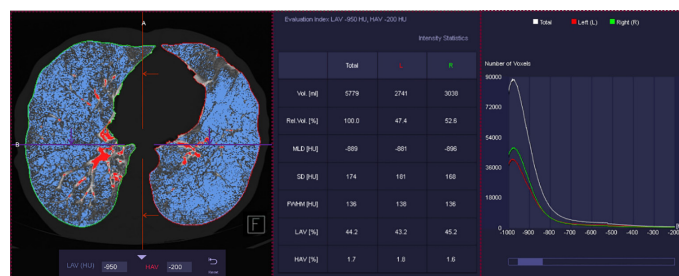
Measuring the Quantity of Emphysema (LAV%) and Lung volumes. Each result of the reconstruction was processed by using 3D Pulmo software in SYNGO.VIA Siemens workstation to measure the quantity of emphysema by displaying the Low Attenuation Volume (LAV) with HU values of -950 in percentage (%) and lung volumes by showing the symbol of vol in milliliter (ml). The software allows masking the area with certain HU and calculating automatically from Dicom formatted images of HRCT Chest. The area with <-950HU which is detected as emphysema is shown in blue while the airway showed in red.
